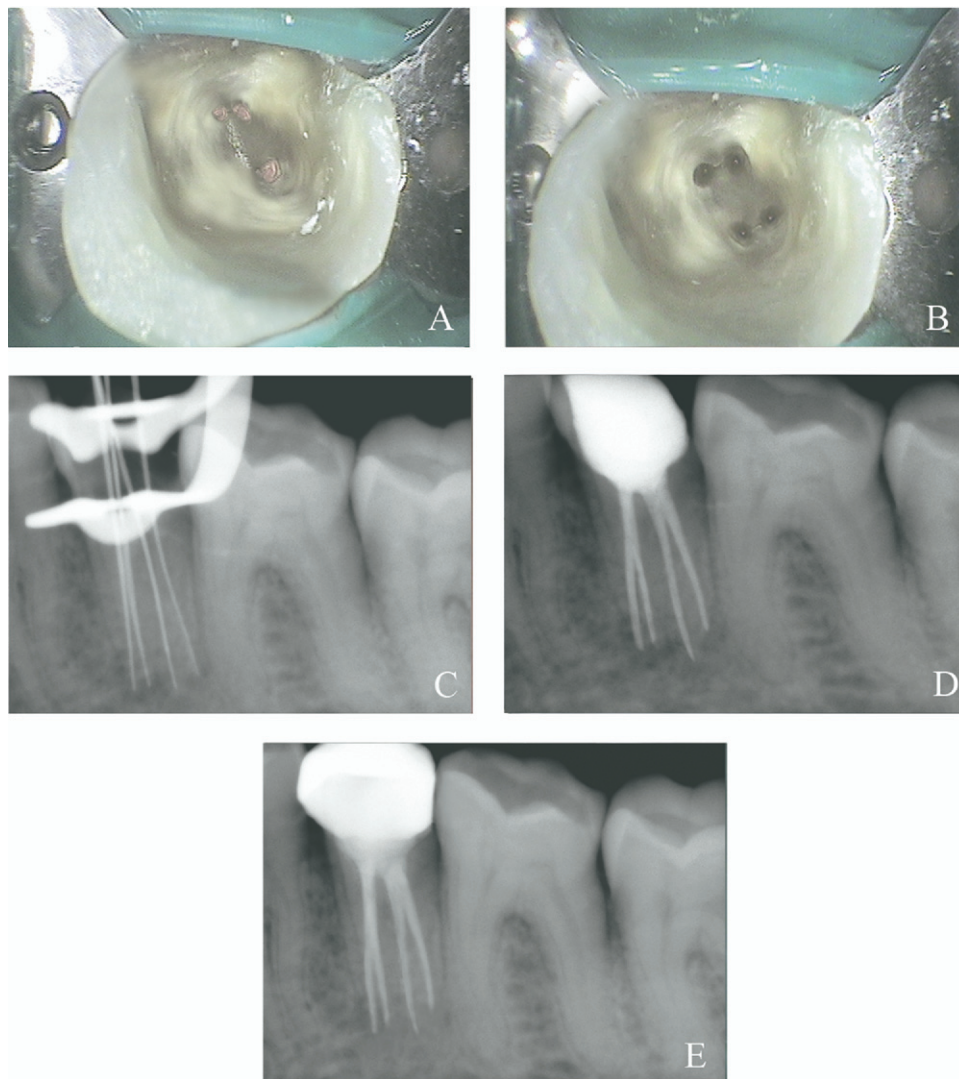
(A) Initial access opening view after the removal of temporary restoration. (B) Access opening showing orifices of the four root canals. (C) Working length determination. (D) Immediate postoperative radiograph. (E) Recall radiograph 1 year postoperatively.
